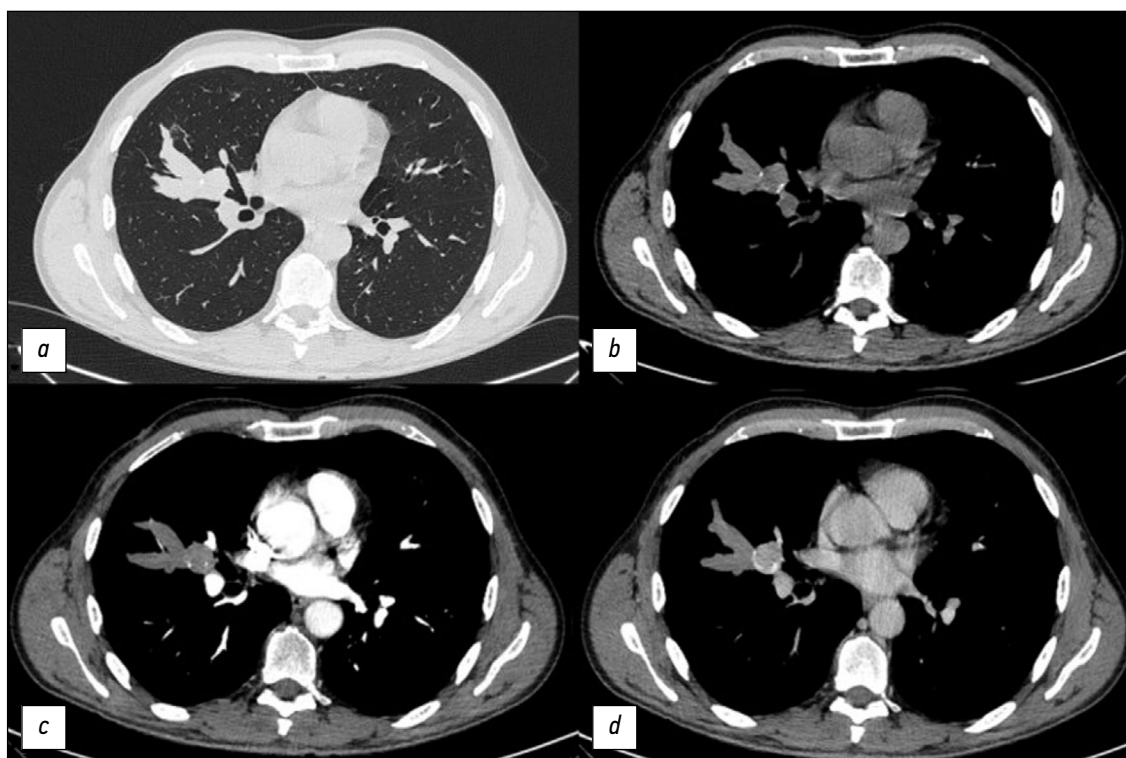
Computed tomography scan of the chest cavity organs in the axial plane in the same patient: *a*, lung window; round lesion at the base of the bronchocele was detected during the native phase; *b*, mediastinum window; single calcifications along the periphery of the lesion were noted; *c*, mediastinum window; arterial phase; *d*, mediastinum window; signs of contrast accumulation by the lesion were detected in the venous phase.
